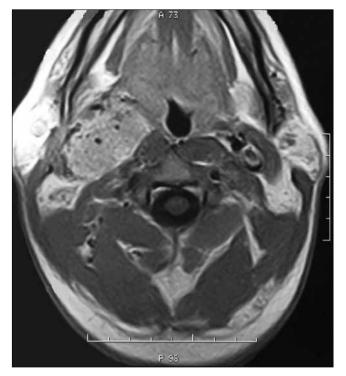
T1-weighted magnetic resonance imaging showing the typical salt-and-pepper pattern of the malignant paraganglioma.
